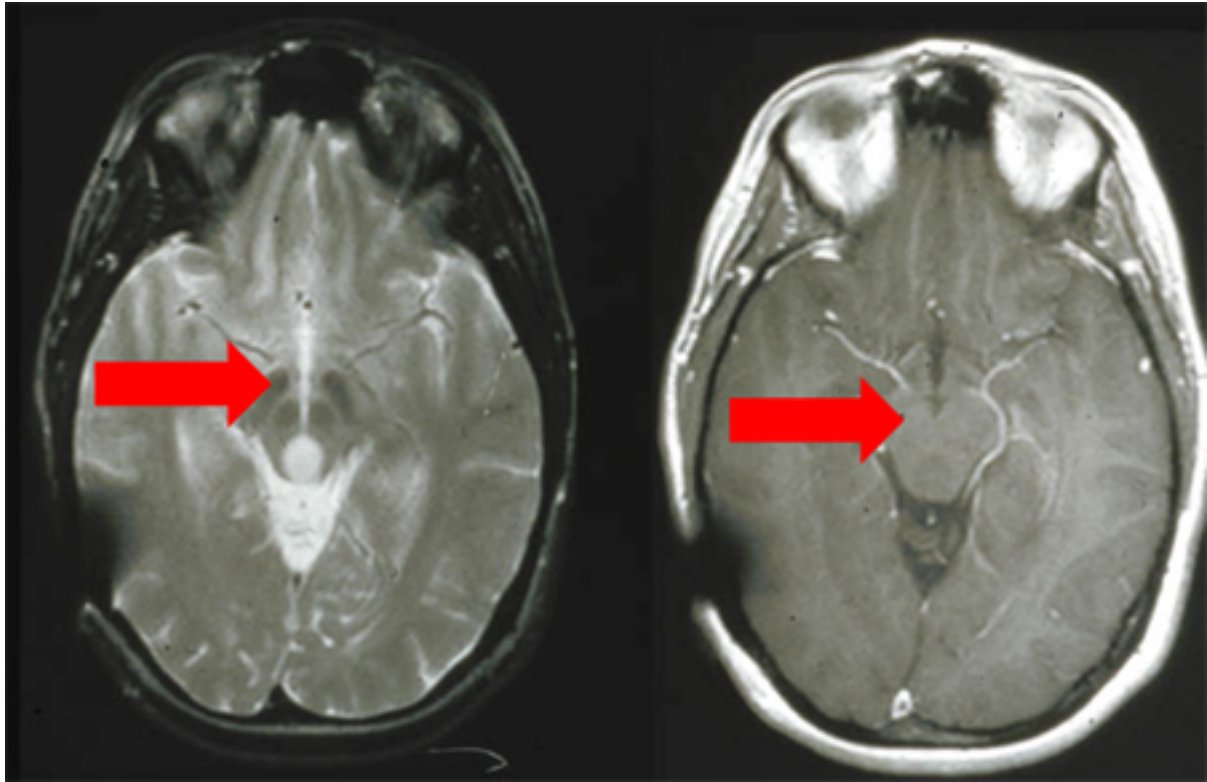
MRI: T2 and T1 post-contrast, demonstrating a tectal glioma (grade II).
